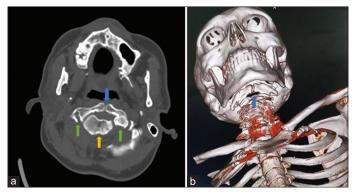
(a) Axial bone window CT at the level of C1 vertebra shows a fusion defect of its anterior arch (blue arrow) as well as posterior arch (green arrows). Odontoid process of C2 (yellow arrow) is expanded and globular; (b) 3D reconstruction shows the fusion defect of anterior C1 vertebral arch (blue arrow)
